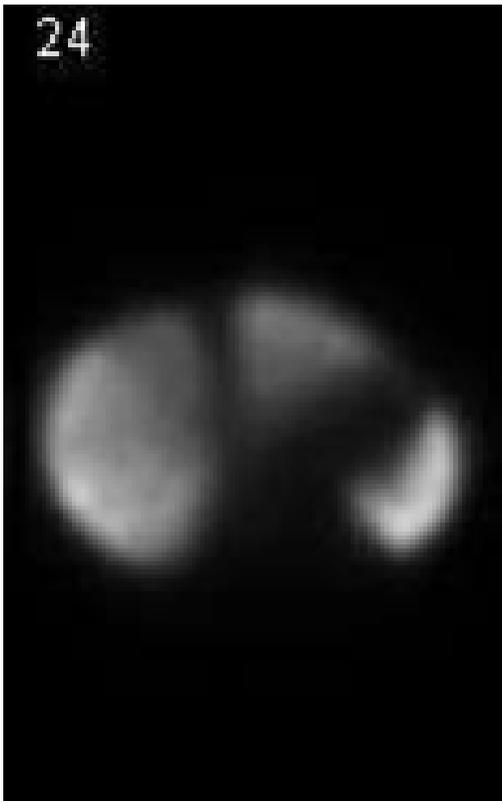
Axial SPECT is visibly more heterogeneous for a 44 year-old woman with polyglandular failure, factitious hyperthyroidism (found taking 225 mcg Synthroid twice daily) and morbid obesity, BMI 42.4. She had abnormal transaminase, more prominent shift of colloid to the spleen, borderline splenomegaly and Sn 3.544, consistent with hepatic steatosis more marked than Sn 2.90+/-0.521 in patients with hepatic steatosis and no thyroid disease. In this patient Sw -0.7962 was less negative than usual, suggesting less heterogeneity in the areas of more impaired liver function. Also of interest is the photopenic wedge-shaped division between the right and left lobes of the liver.
